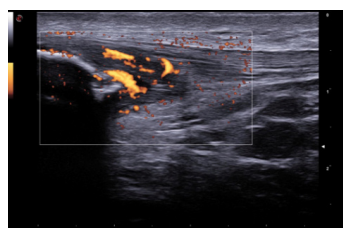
Power Doppler technology.
